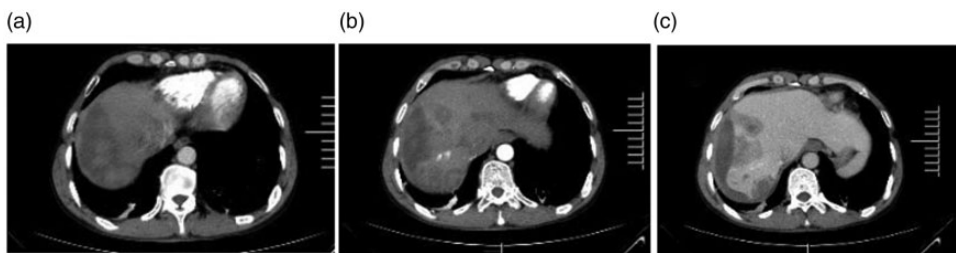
Computed tomography scans of the liver of a 55-year-old male patient that presented with right upper quadrant distending pain for the previous 15 days prior to admission: (a) localized fluid accumulation under the right hepatic capsule was observed, with uneven density, patchy slightly high-density shadow and no enhancement; (b) arterial phase imaging showing multiple patchy low-density lesions in the right lobe of the liver and inhomogeneous enhancement in the arterial phase; (c) delayed phase imaging showed low density shadow.
